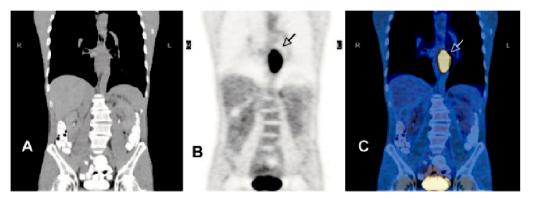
Integrated PET/CT of a patient showing NPA = 1 in the primary (arrow). (A) CT scan; (B) PET scan; (C) integrated image.
